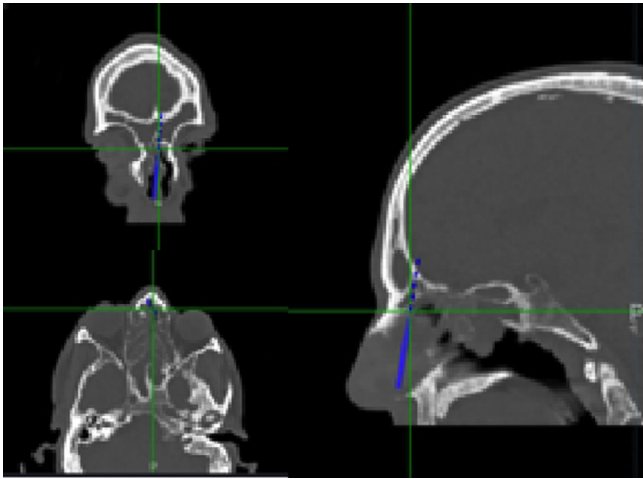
Computed tomography (CT) navigation image of the medial canthal point (MCP) along the skull base
